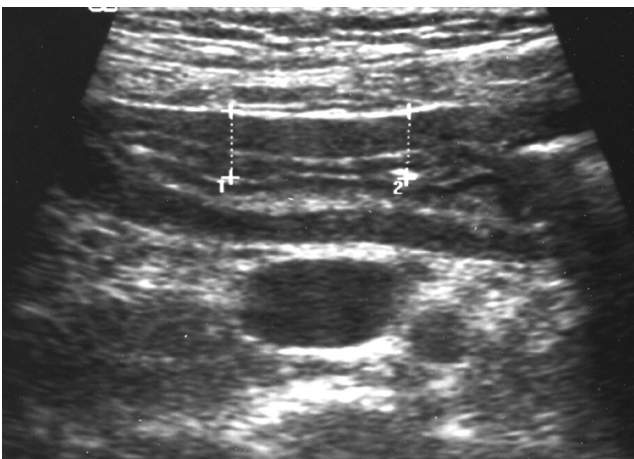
Transabdominal ultrasonography in a patient with gastric ulcer. In the transverse scan, the mean thickness (calipers) of gastric wall measured about 8.3 mm. The stratification of wall is also preserved.
